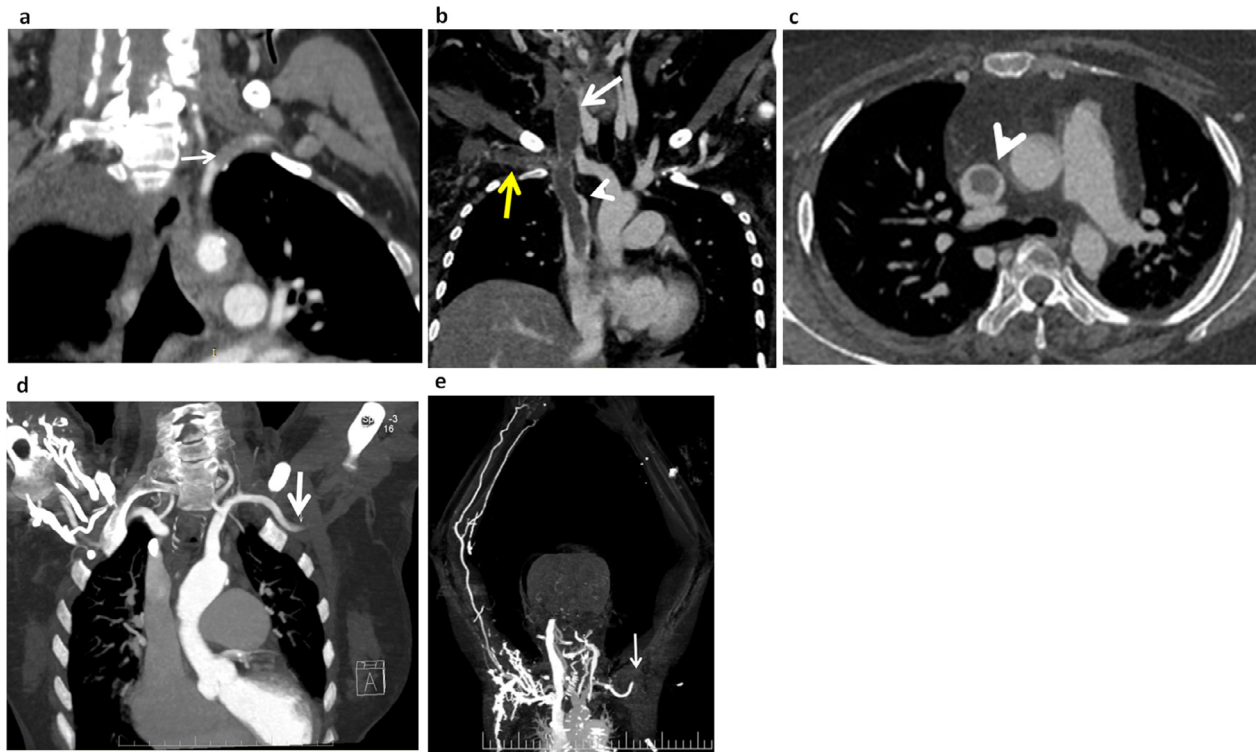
Thromboembolic complications in different COVID positive patients. (A) Subclavian artery thrombosis. Coronal reformatted CECT reveals a hypodense filling defect in the left subclavian artery (B, C) Superior vena cava (SVC) thrombosis. Coronal reformatted (B) and axial (C) CECT reveals large hypodense filling defect in SVC (white arrowhead B,C) extending to right internal jugular vein (white arrow b) and right subclavian vein (yellow arrow B). (D,E) Axillary artery thrombosis. Coronal maximum intensity projection (MIP) images of CT angiography revealed sudden cut-off of left axillary artery suggesting thrombotic occlusion (white arrow) (Color version of the figure is available online.).
